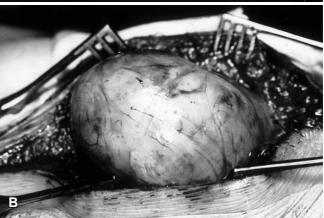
Imaging of the tumour. A Axial CT of the right shoulder showing a well-circumscribed soft tissue mass with irregular trabeculae of bony density closely connected to the right scapula. B Intraoperative photograph showing a well-demarcated oval tumour with a thin fibrous capsule
